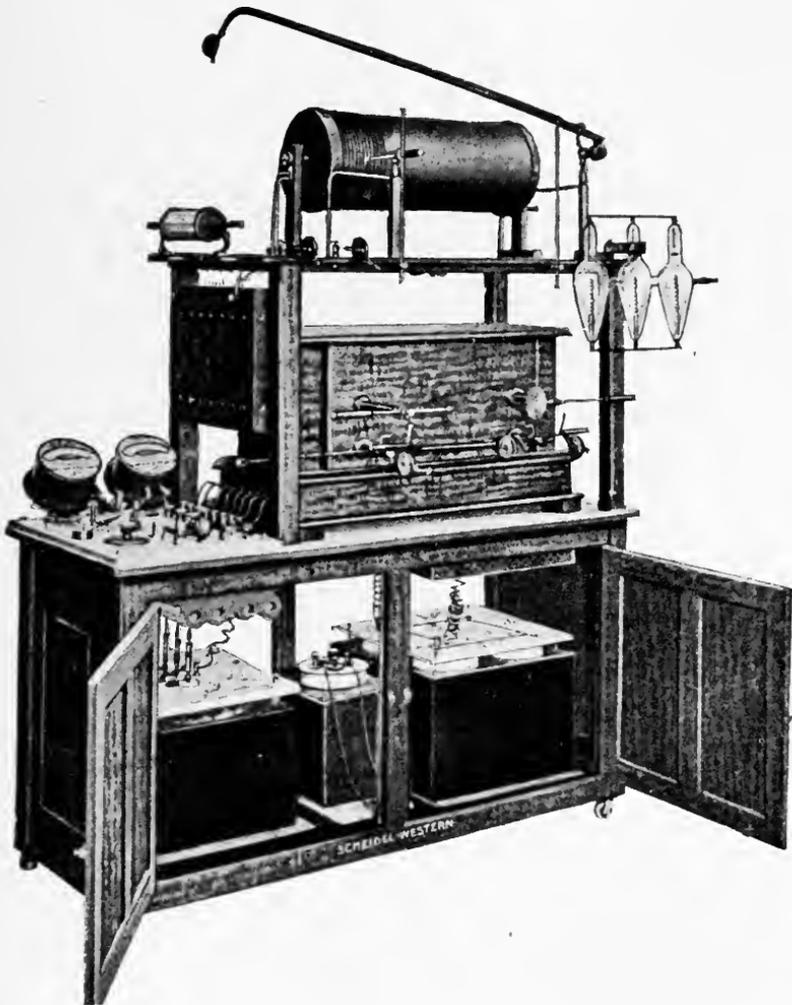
INDUCTION COIL TYPE OF APPARATUS FOR PRODUCING X-RAYS.
